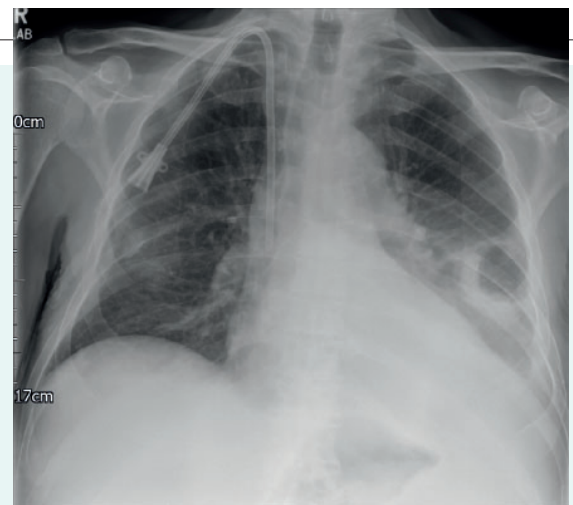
Erect chest radiograph, anteroposterior projection
